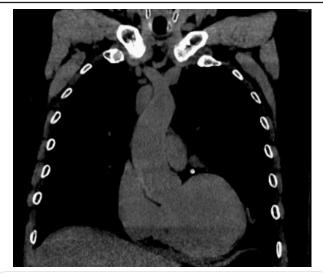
Coronal view Follow up CT. 2 days after PCI. Unenhanced coronal view demonstrates the presence of a lunate image, spontaneously hyper dense in the unenhanced phase compatible with intramural hematoma of 7mm thick with resolution of the extra luminal-pooled contrast. The study did not demonstrate any ongoing dissection.
